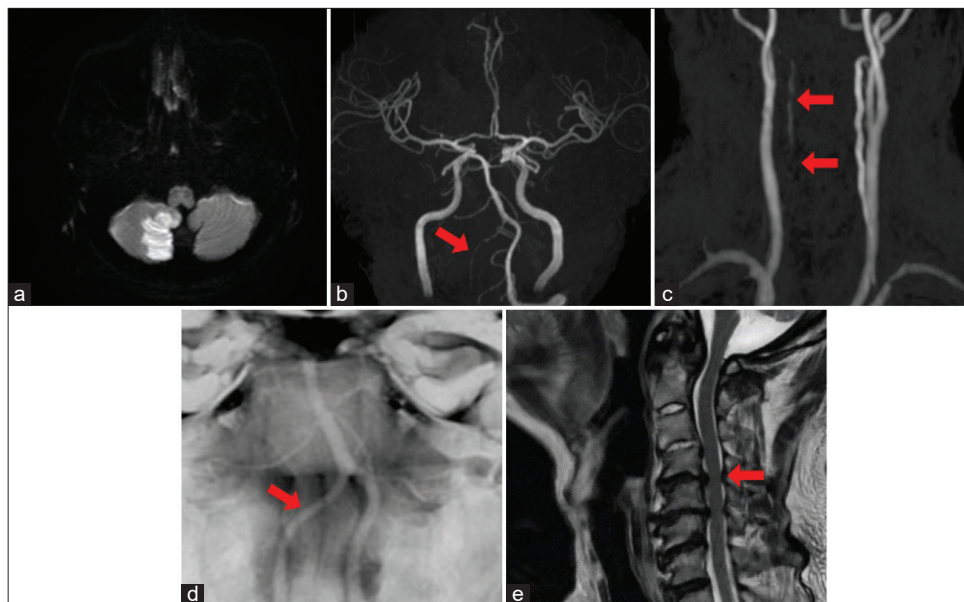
Magnetic resonance imaging on admission. (a) Diffusion-weighted image showing high-intensity area in the right cerebellum. (b and c) Faint opacification of the right VA (arrow). (d) BPAS demonstrating the diameter of the right VA is smaller than that of the left (arrow). (e) Stenosis of spinal canals at C4/5 (arrow) in addition to C5/6.
